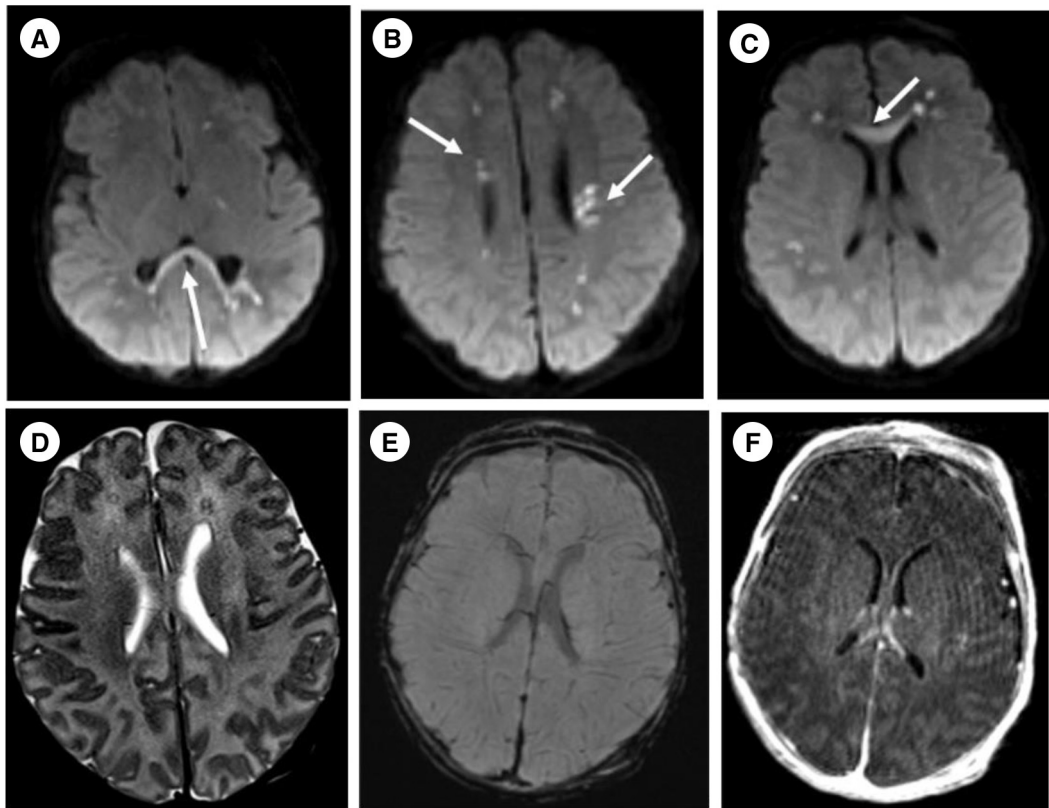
Axial diffusion-weighted images (A-C) at nine days of age showing multiple foci of restricted diffusion in the periventricular and deep white matter and corpus callosum (arrows). Axial T2 weighted image (D) shows corresponding signal abnormality in the deep white matter (arrows). There is no hemorrhage or enhancement associated with these white matter regions of signal abnormality as seen on susceptibility weighted (E) and postcontrast T1-weighted (F) images.
